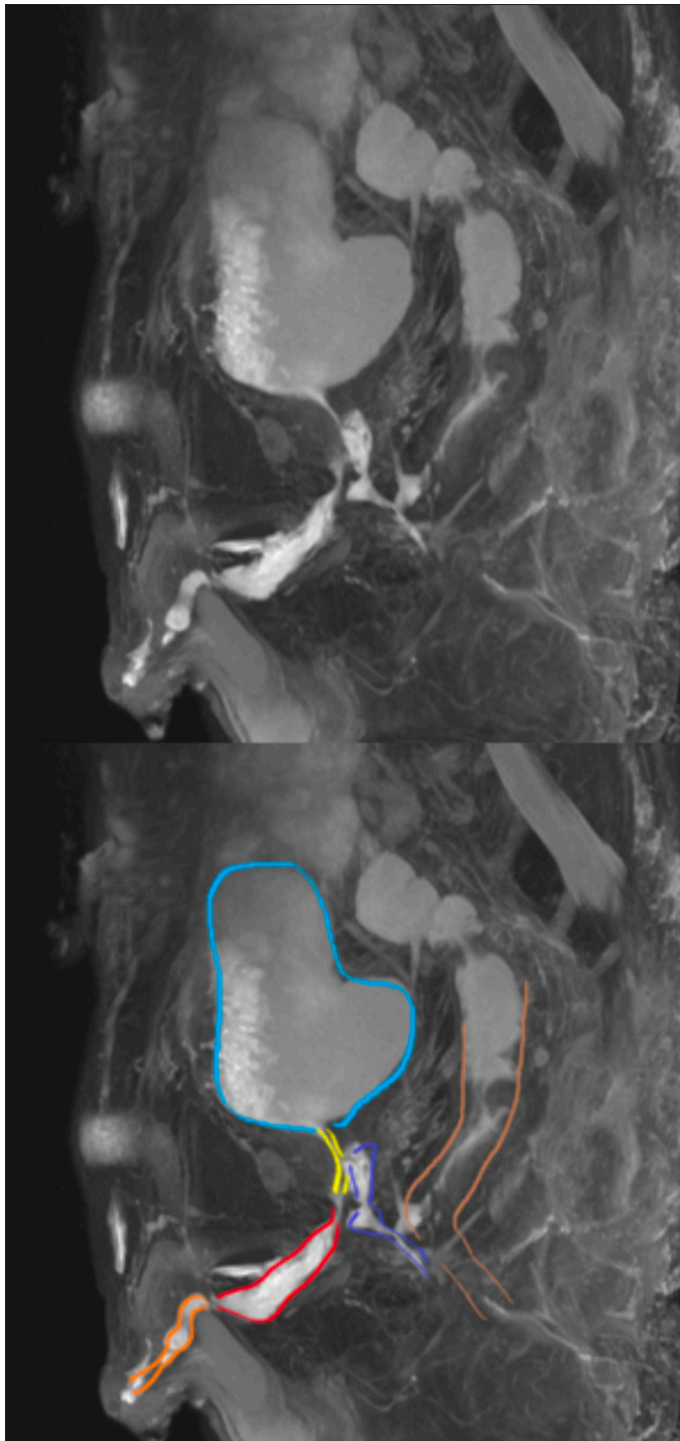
Magnetic resonance imaging (MRI) with our technique in patients with rectourethral fistula
